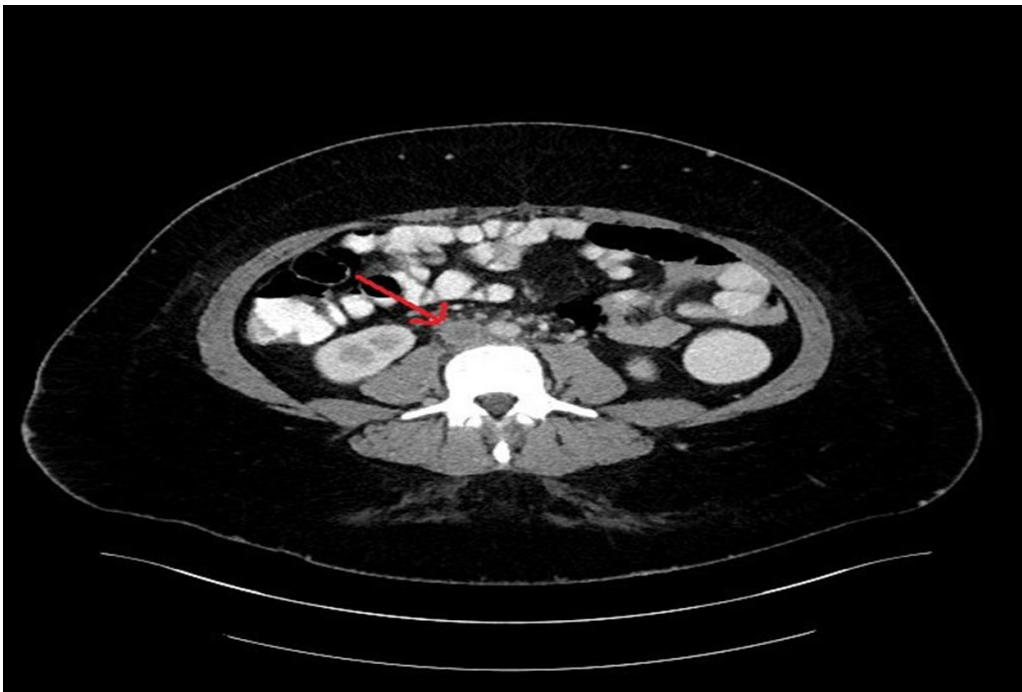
IV Contrast enhanced CT scan of the abdomen and pelvis showing Occlusion of the IVC (red arrow) and right EIV (yellow arrow) as shown in figure 5.
